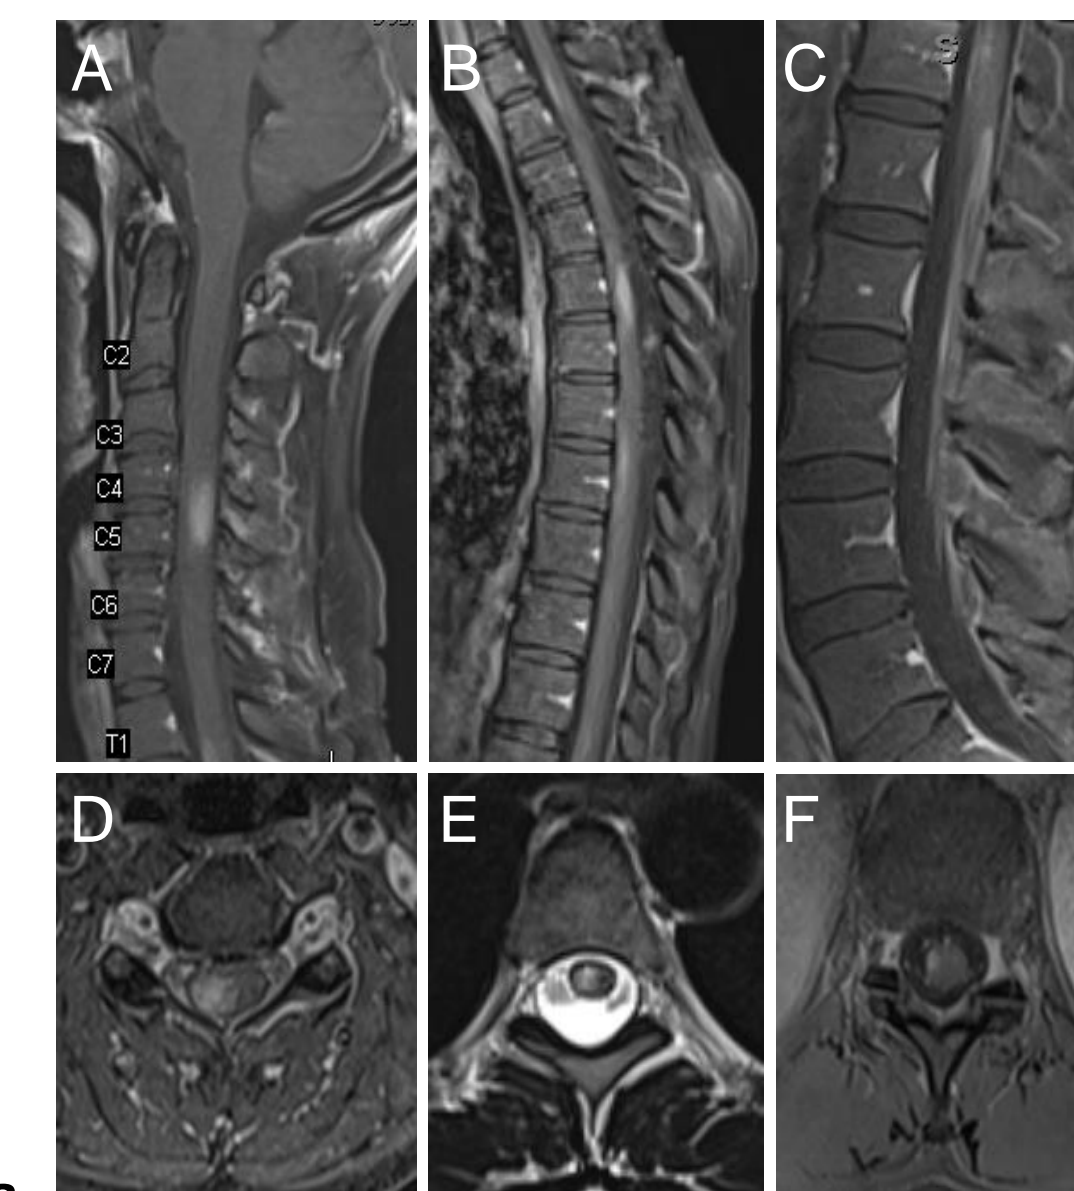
T1-weighted post-gadolinium MRI of spinal cord demonstrating multifocal enhancing lesions at presentation. A, D cervical spine. B, E thoracic spine, and C, F cauda equina.
